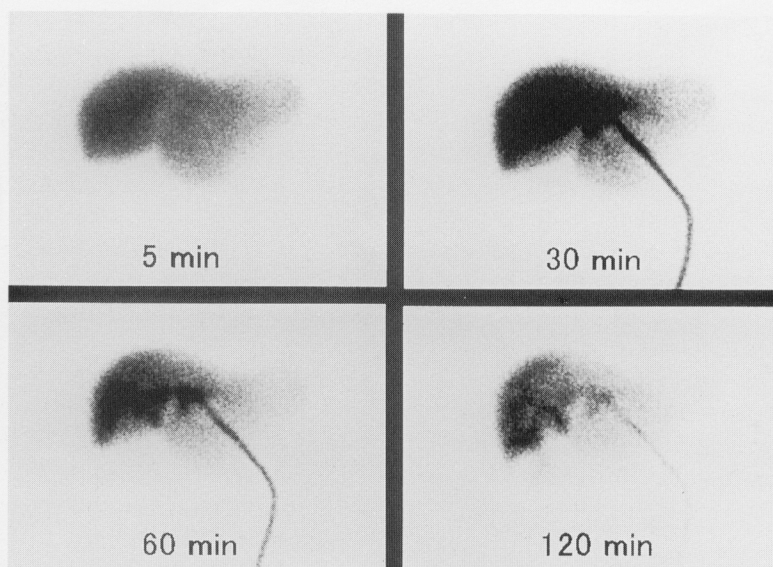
Hepatobiliary scintigraphy with Tc-99m PMT demonstrated normal accumulation of the radioisotope in both lobes. Although normal bile excretion was found from the left hepatic duct to the PTBD tube, excretion from the right hepatic lobe was markedly prolonged.
